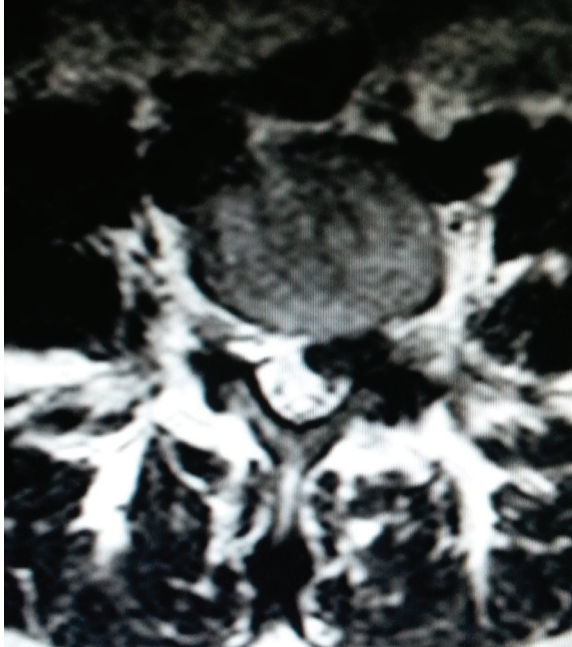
Axial T2-weighted MRI showed left-sided posterolateral extruded disc fragment at the L4-5 level (a 48-year-old male with axial sign; physical therapy was recommended after medical treatment)
